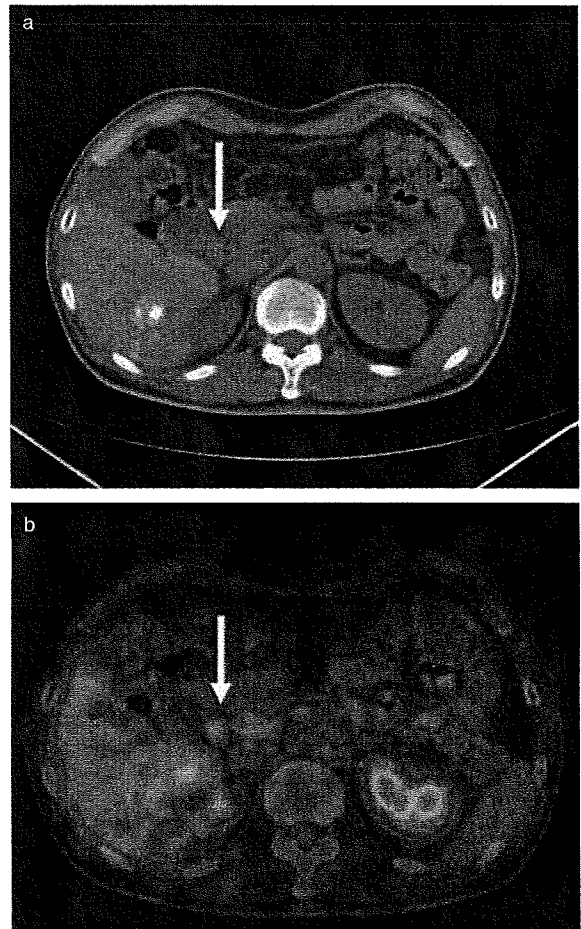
A 62-year-old male patient with hepatocellular carcinoma (HCC). This patient had lymph node swelling measuring 12 mm in diameter in the abdomen (a). The lesion was detected by multi-detector helical computed tomography (MDCT) (white arrow). However, the size of this lesion did not change over a 6-month period and the tumor marker was negative (b). The maximum standardized uptake value (SUV) was 2.7 in positron emission tomography - computed tomography (PET-CT) (white arrow) and this lesion was diagnosed as benign.
